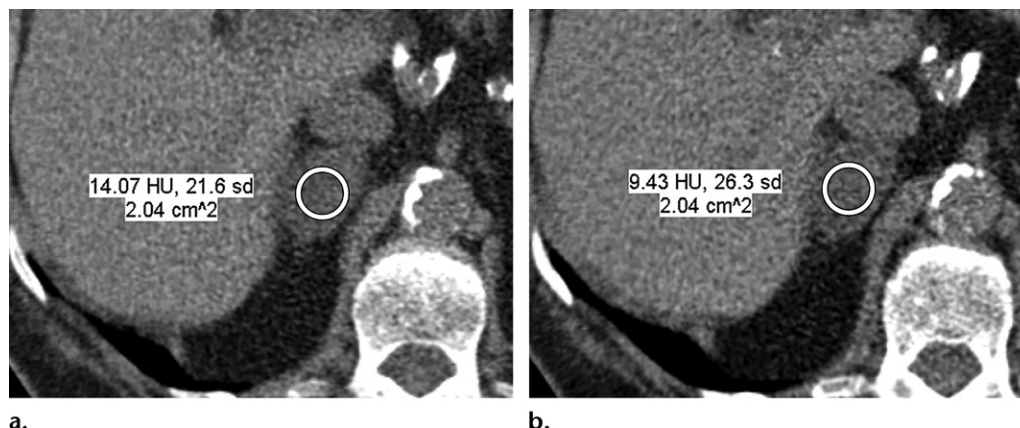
Attenuation values at differing tube voltages. Axial nonenhanced dual-energy CT images show a right adrenal nodule with an attenuation of 14 HU at 140 kVp (tin filtered) (a) and 9 HU at 100 kVp (b). These attenuation values are contradictory for diagnosing a lipid-rich adenoma (a nonenhanced CT attenuation ≤ 10 HU is used to diagnose lipid-rich adenomas). However, the reduction of attenuation values on lower kilovolt peak images suggests the presence of lipid content. A diagnosis of a lipid-rich adrenal adenoma can be inferred from the data without the need for further imaging.
